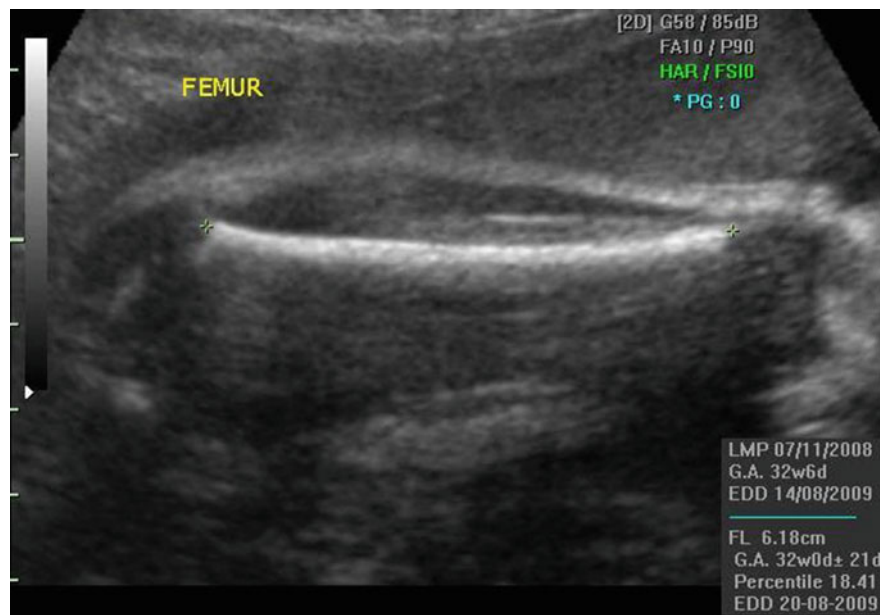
The fetal femoral length can also be measured in an ultrasound image
